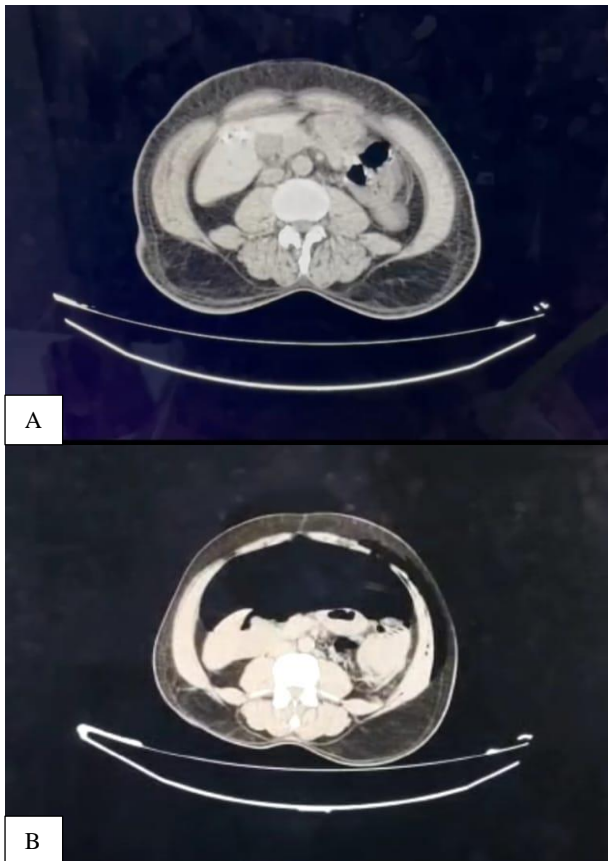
(A and B): CT image pre and post pneumoperitoneum creation. Pre pneumoperitoneum creation and post pneumoperitoneum creation
